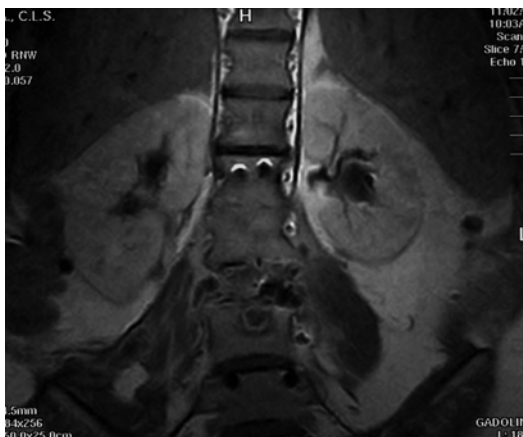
A 46-year-old female patient. MRI lumbar spine hydatid lesions in L3 (Courtesy of A. Herrera, MD, PhD)
